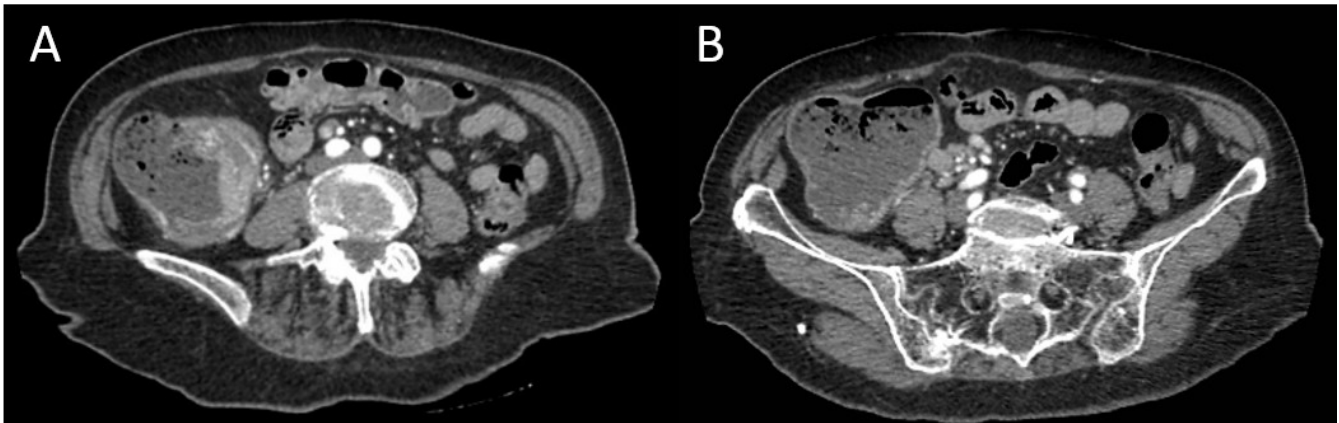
CT scan: (A) Irregular wall thickening of the cecum and retrograde dilation of the loops. (B) Reactive ganglia para-aortic and right colics.
